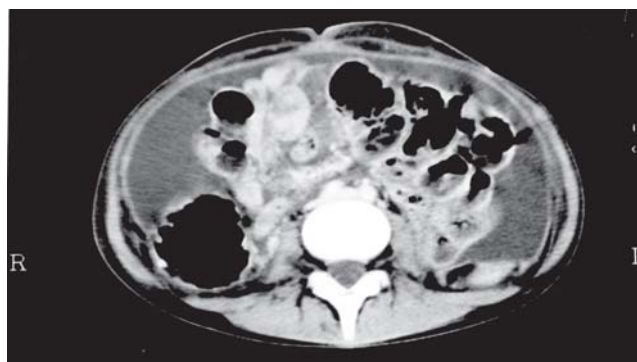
Abdominal computed tomography image at time of diagnosis of sclerosing encapsulating peritonitis, showing adherent bowel loops, with posterior tethering and luminal narrowing, peritoneal thickening, and loculated fluid.
